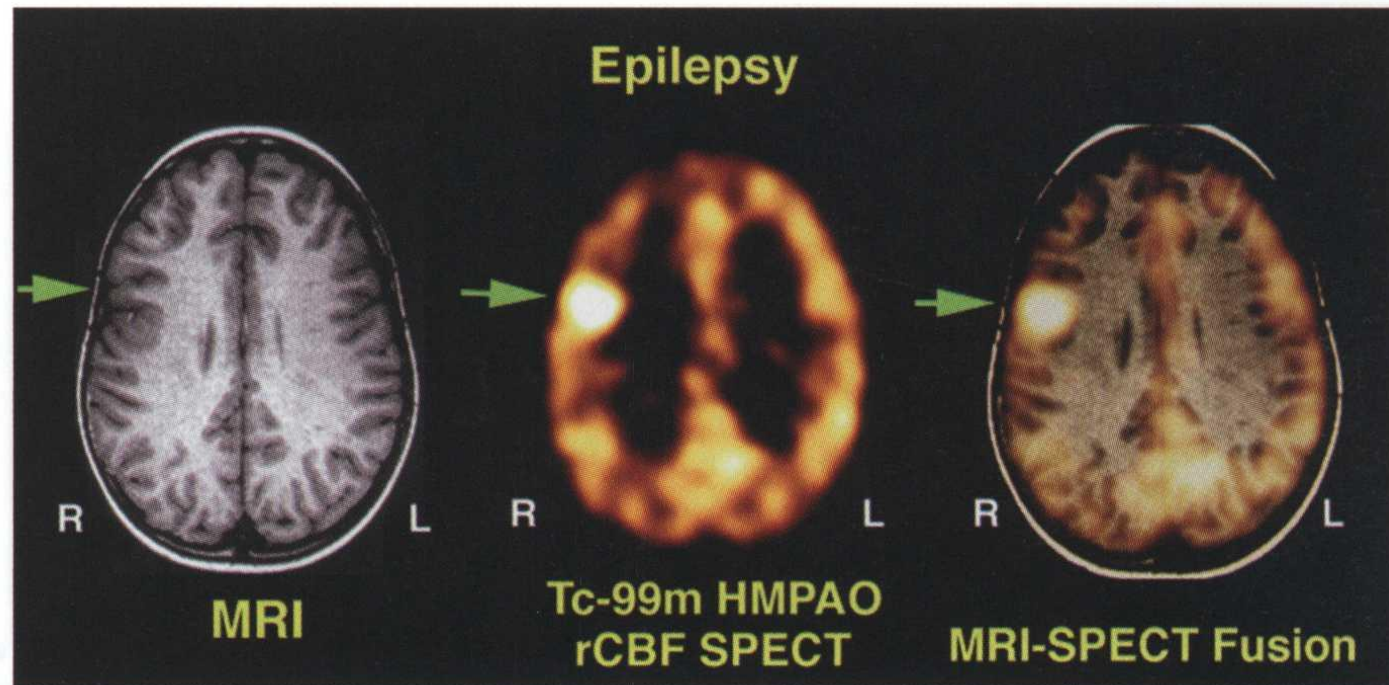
Epilepsy (ictal). Sagittal and coronal SPECT brain perfusion images obtained with the radiopharmaceutical ^{99m}Tc -HMPAO during seizure show markedly increased activity in the right parietal cortex (*arrows*), indicating increased perfusion of the epileptogenic focus. (Case courtesy of B. Barron, M.D., and Lamk Lamki, M.D.)
